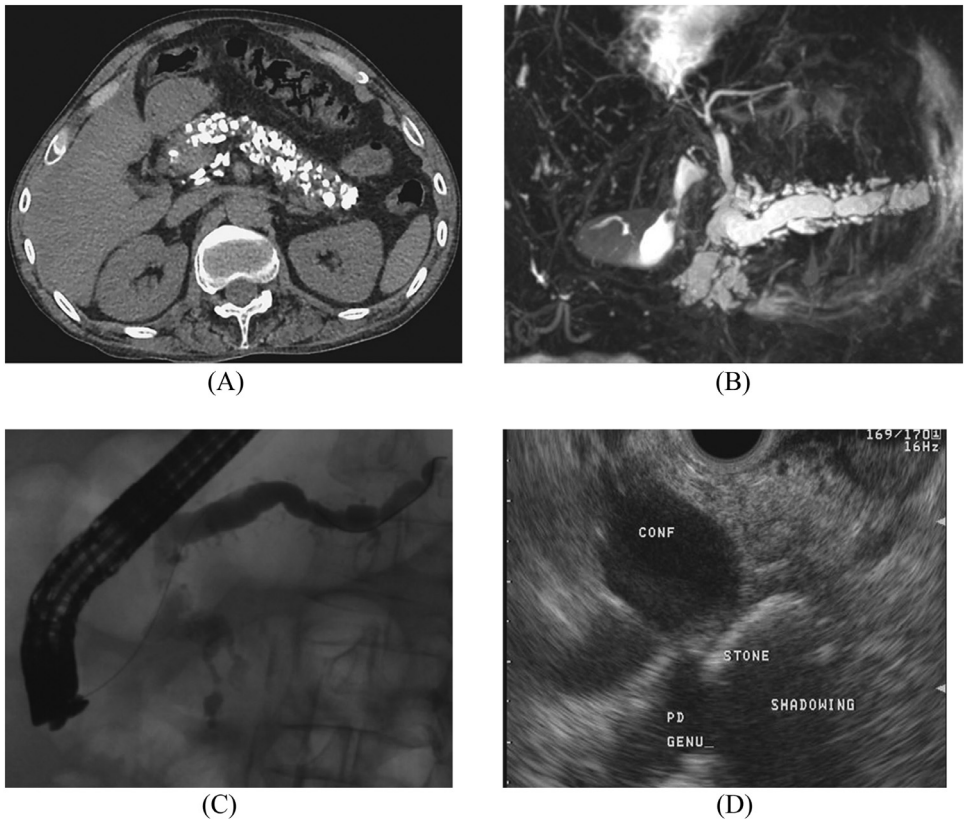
Diagnostic imaging and characteristic findings in chronic pancreatitis. (A), CT with significant pancreatic parenchymal calcification and atrophy. (B), Secretin-enhanced magnetic resonance cholangiopancreatography (MRCP) demonstrating dilation of the main pancreatic duct with dilated and ectatic side-branches. (C), ERCP displaying dilation of the main pancreatic duct, side-branch irregularities, and irregular duct contour (Cambridge grade V). (D), Endoscopic ultrasound demonstrating detailed view of pancreatic duct anatomy. PD GENU_, pancreas neck; STONE, stone in main pancreatic duct with posterior acoustic shadowing.
